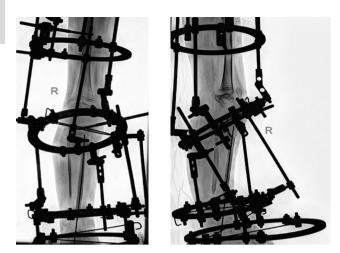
Intraoperative radiographs of the right tibia bones in two views after microsurgical transplantation
